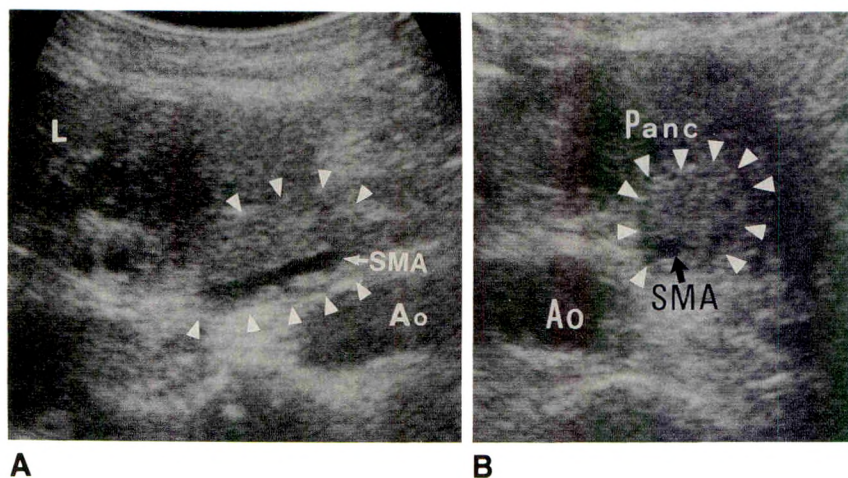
A, Cuff sign in a 68-year-old woman with cancer of pancreas and involvement of superior mesenteric artery (SMA). Longitudinal sonogram shows thickening of root of SMA measuring 10.2 mm. Lumen of SMA is preserved. Arrowheads indicate cuff. L = liver, Ao = aorta.
